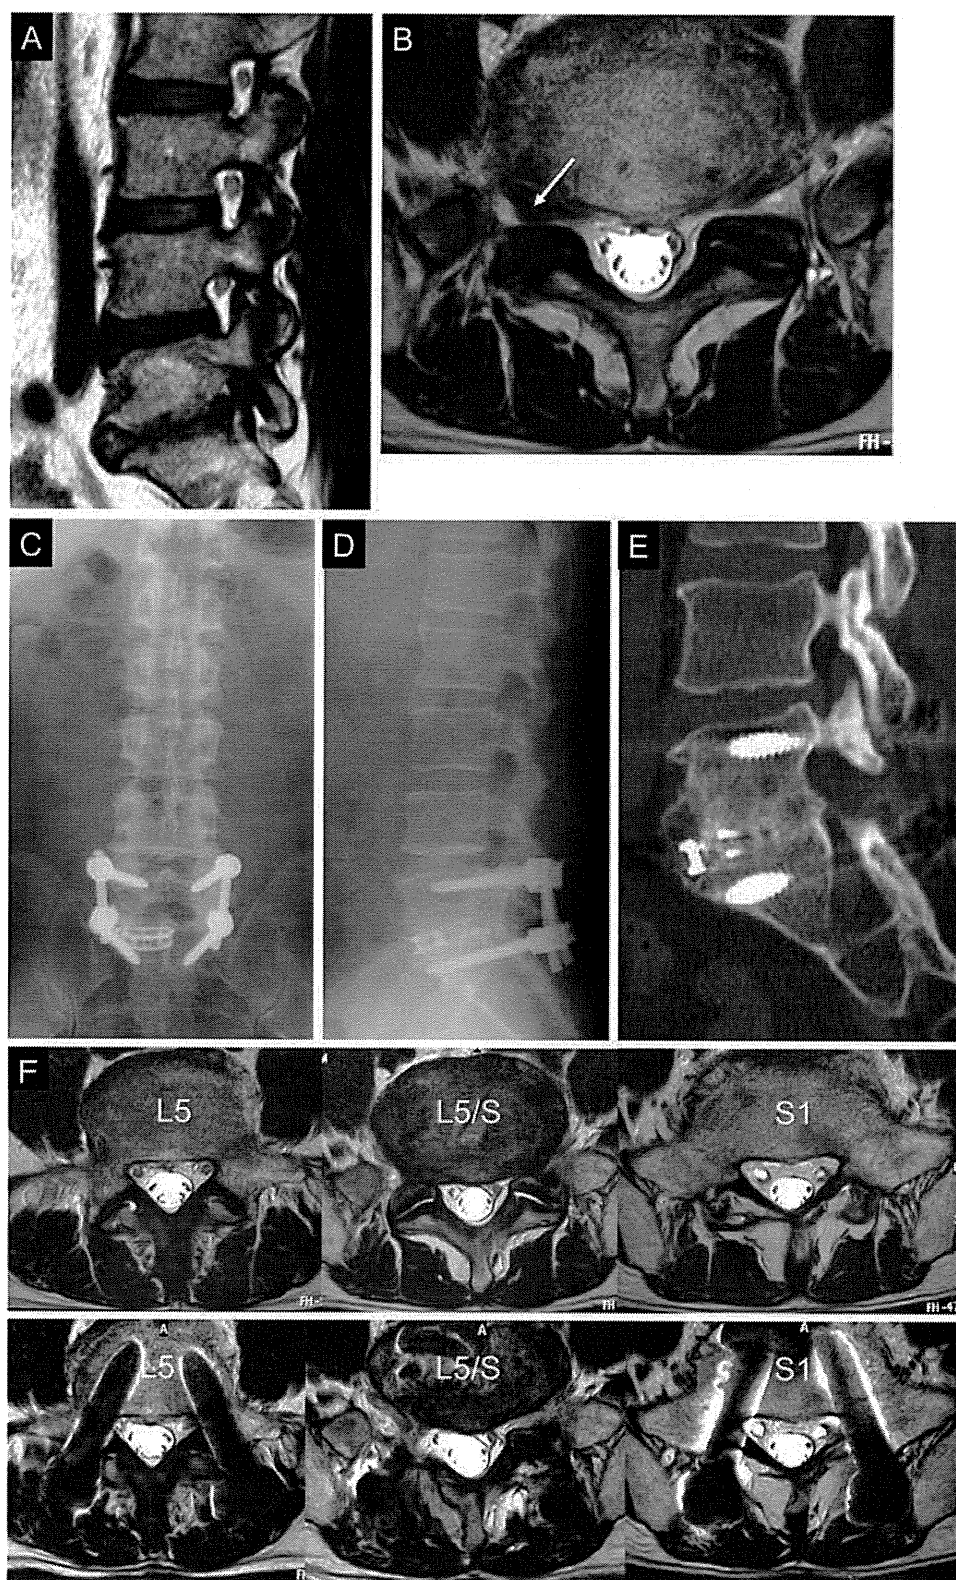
Case 6. Preoperative and postoperative radiological studies obtained in a 58-year-old man with foraminal stenosis combined with lateral disc herniation at L5-S1. A: Parasagittal MR image demonstrating foraminal stenosis with a Modic change of the vertebral endplate. B: Axial MR image demonstrating foraminal stenosis with lateral disc herniation (arrow) on the right side at the L5-S1 level. C and D: Anteroposterior and lateral radiographs demonstrating good positioning of the interbody cage and PSs. E: Sagittal reconstruction CT image demonstrating solid bony union into and around the cage 6 months after surgery. F: Axial MR images demonstrating minimal changes in the paraspinal muscles before surgery (upper) and 6 months after surgery (lower).
